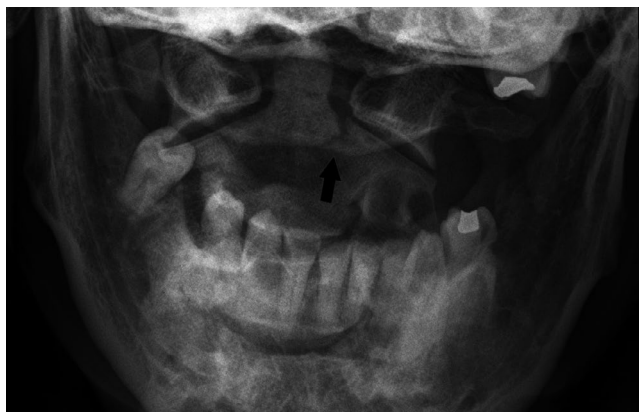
Open Mouth Odontoid View X-Ray showing a type III odontoid fracture
